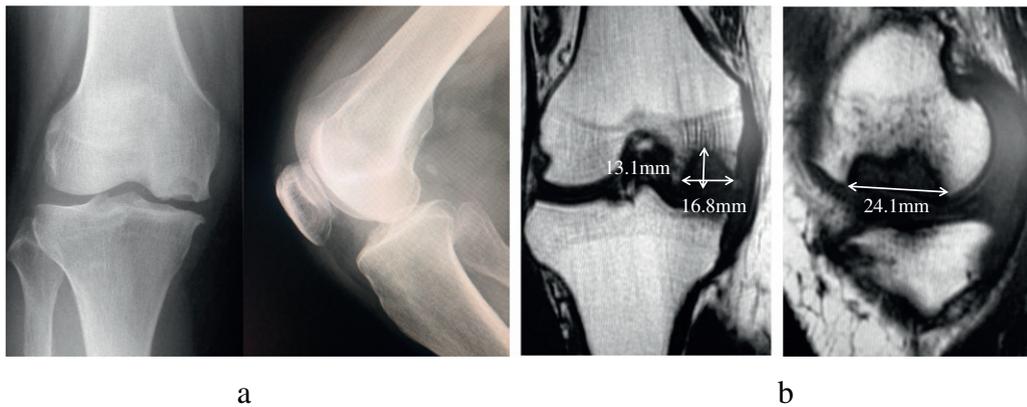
67 year-old female patient a) radiographs. b) MRI with 5.3 cm³ of necrotic tissue in juxta articular part of the right medial femoral condyle
